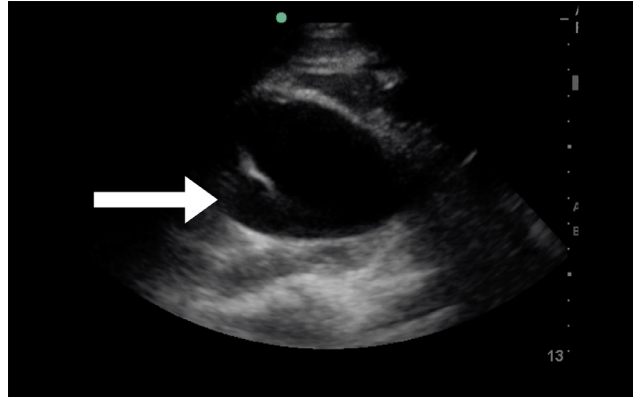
Point-of-care ultrasound of the left kidney demonstrating severe hydronephrosis. Arrow denotes the significant dilation of the renal pelvis seen in severe hydronephrosis.
